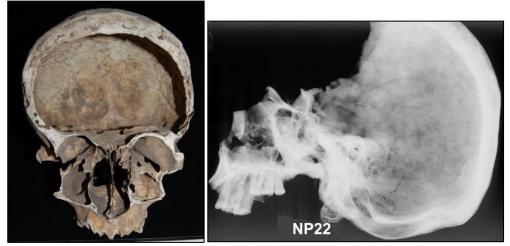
Cranial PDB thickening (left) and x-ray (right) of NP22. X-ray image: © University of Bradford.
